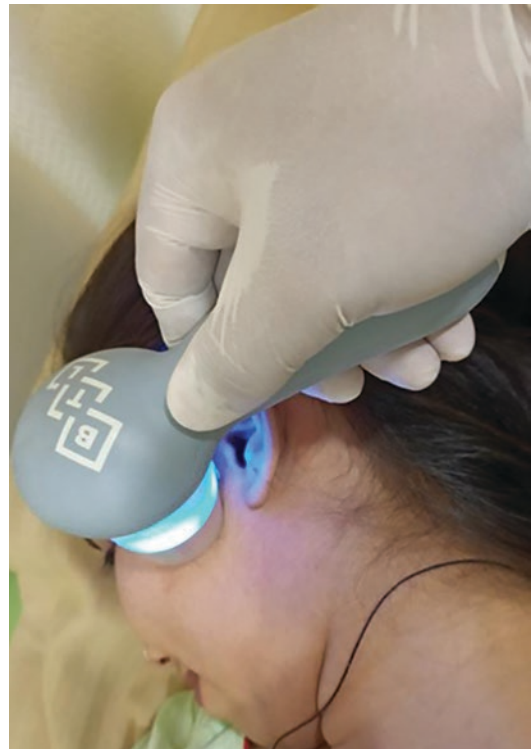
Ultrasound physiotherapy in the TMJ region
